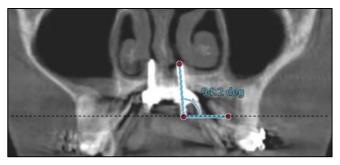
"A°TL" parameter: CBCT image in the coronal plane.
